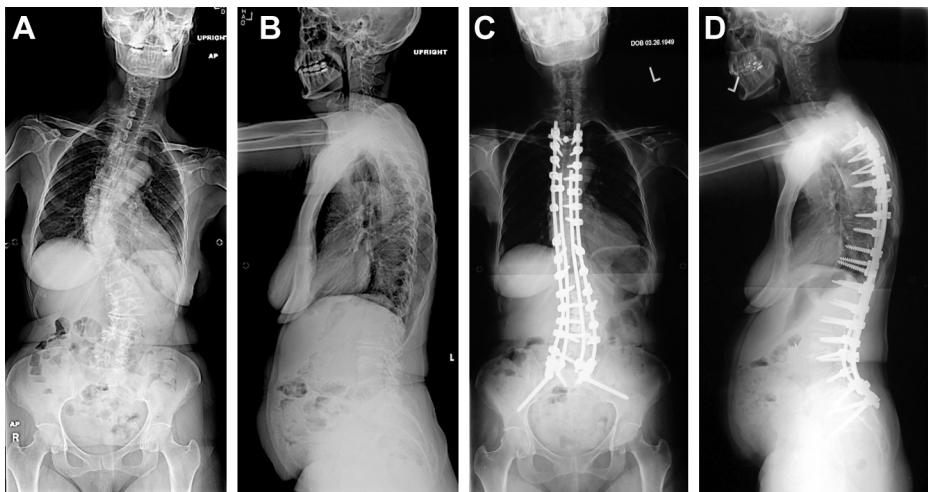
Outrigger quad-rod reconstruction for neglected adolescent idiopathic scoliosis with poor osseous healing potential; (A) preoperative anteroposterior (AP) and (B) lateral scoliosis radiographs; postoperative (C) AP and (D) lateral scoliosis radiographs.
